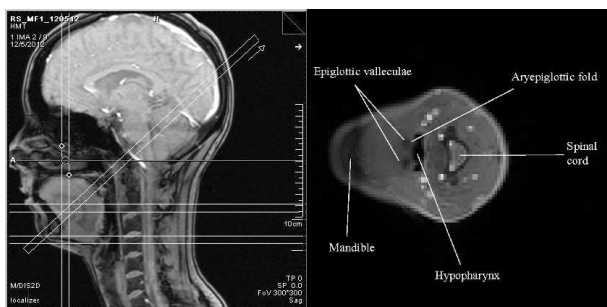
Orientation of MRI slices (left) and example of LP slice with anatomical structures labeled for reference (right).
